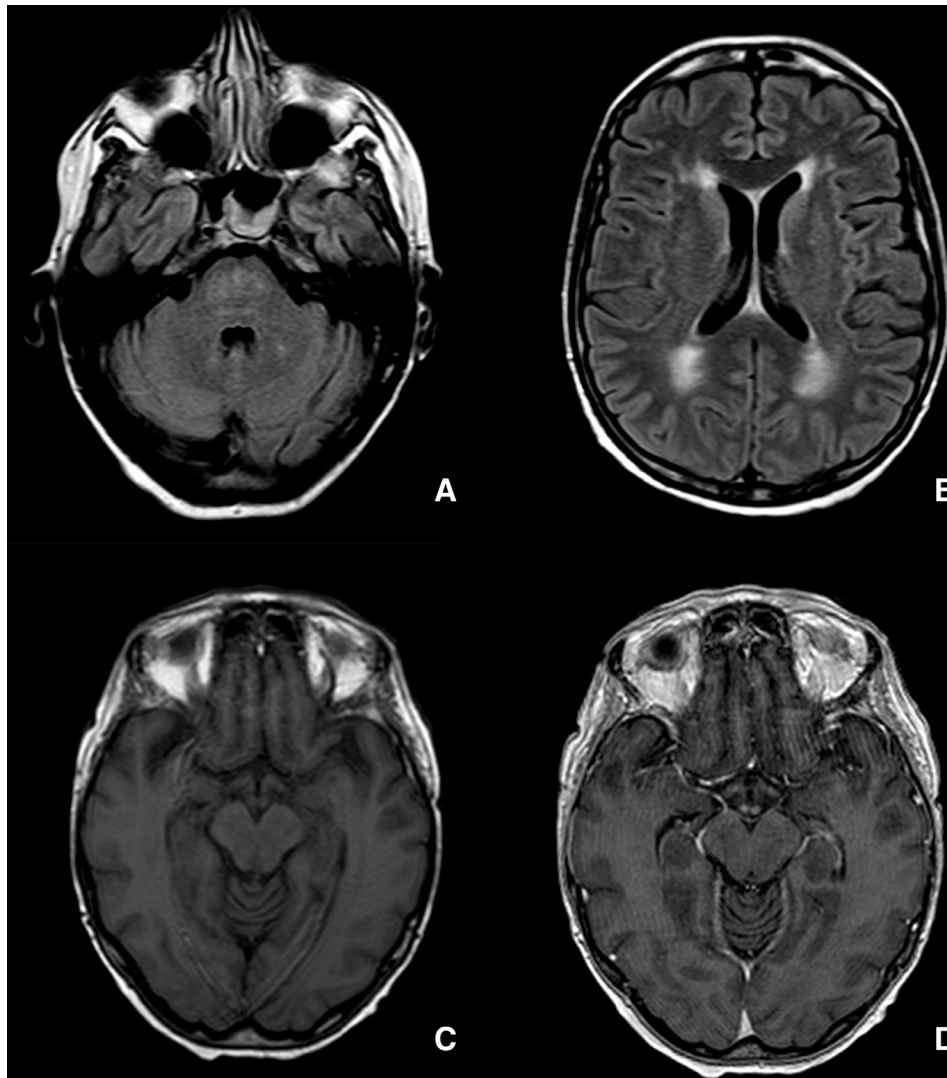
MRI at discharge. T2-FLAIR (A, B), T1 Turbo Spin Echo (C), and T1 Fast Field Echo on axial plane after gadolinium-based contrast agent administration (D). The MRI at discharge showed reduction of T2-hyperintensity of the parieto-occipital white matter while persisted the contrast enhancement of mammillary bodies.
